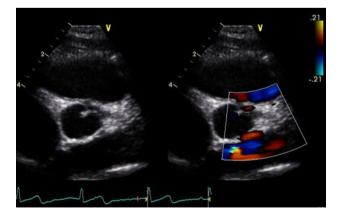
Case 1. Echocardiogram after the unroofing procedure of the intramural portion of the anomalous left coronary artery in two dimensions and with color Doppler
